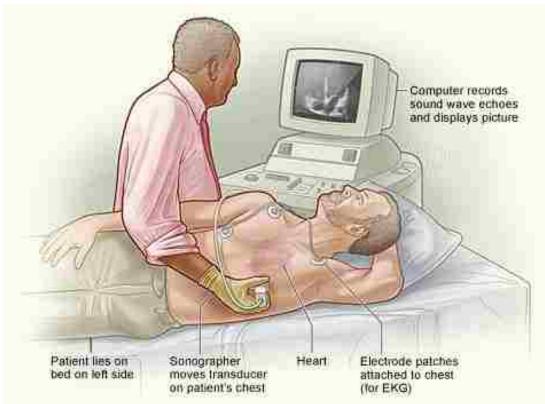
Show a patient having an echocardiography [U.S. Department of Health & Human Services]
